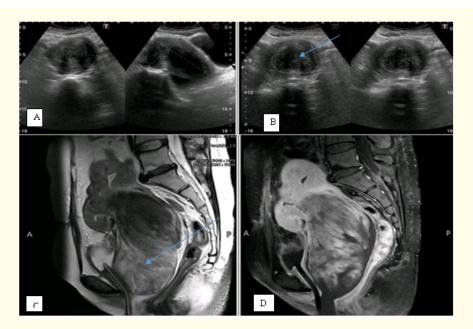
Case Four, US (A, B) done two months earlier showed a submucosal fibroid (arrow). MRI (C, D) shows a large well-defined abnormal signal intensity lesion arising within the endometrial cavity from the anterior wall of the body with a stalk, prolapsing through the uterus and cervix into the vagina, representing a prolapsed pedunculated sub mucosal fibroid (arrow). This shows significant interval increase in size.
